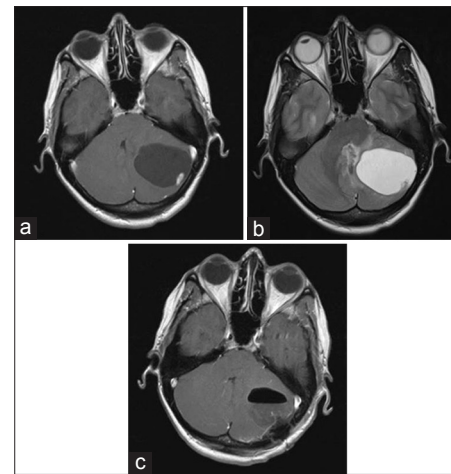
(a) T1-weighted, axial and (b) T2-weighted, axial MRI of a cystic hemangioblastoma localized in the left cerebellar hemisphere, showing the characteristic mural nodule with strong gadolinium enhancement. (c) Postoperative MRI (T1-weighted, axial), confirming total tumor removal and resection of the cystic component after retrosigmoid suboccipital craniotomy. The space-occupying effect and the brain stem compression are alleviated
